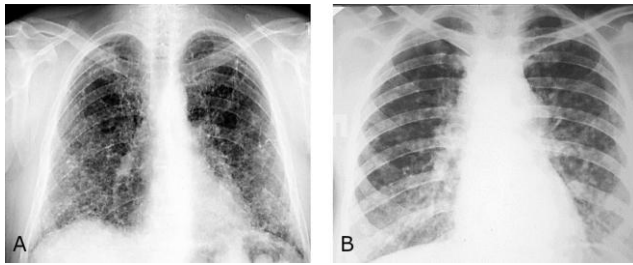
CT picture of disseminated lung TB and lung sarcoidosis; A) Lung sarcoid; B) Disseminated lung TB
